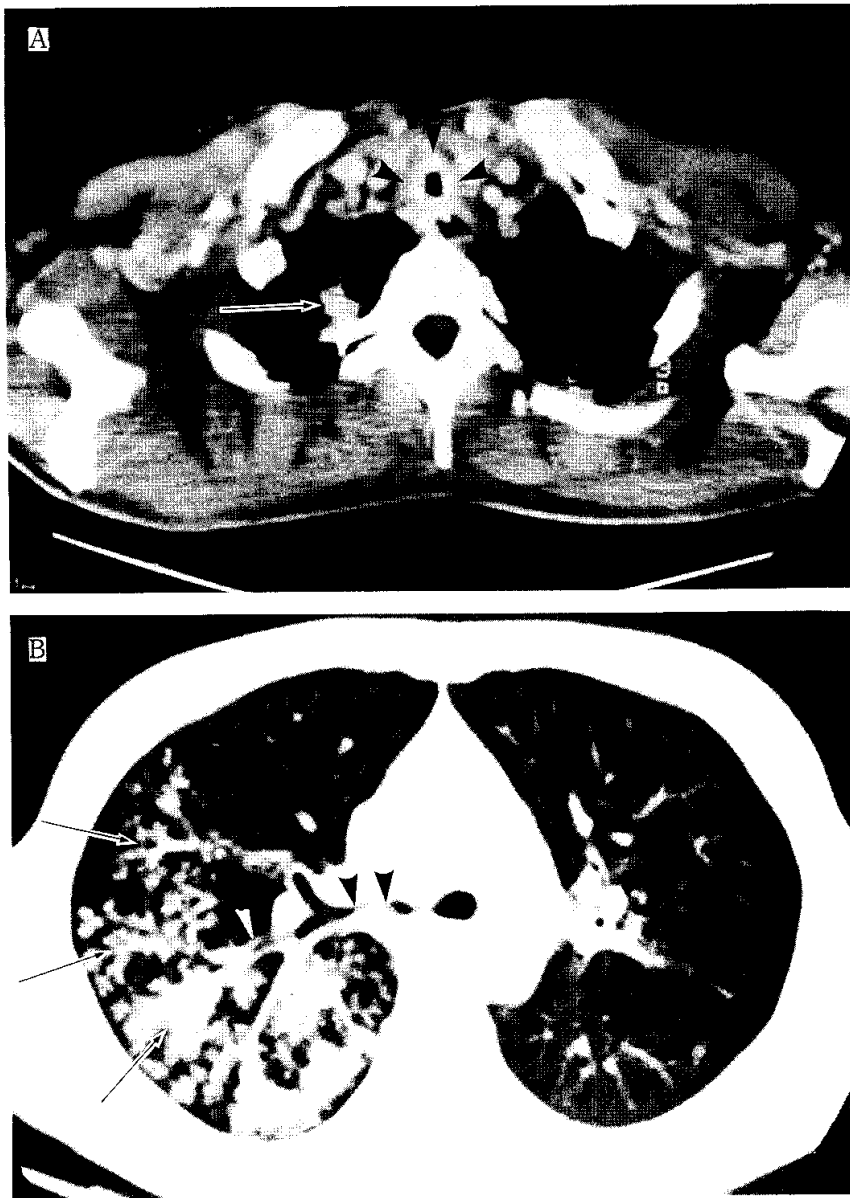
CT scans obtained after injection of intravenous contrast medium in a 35-year-old man with diffuse tracheobronchial tuberculosis. A. Note marked narrowing of the tracheal lumen and enhancing thickened tracheal wall (arrowheads). On bronchoscopy, there were active caseating granulomas on the surface of the trachea and bronchi. Note also nodular pulmonary tuberculous lesion in the right upper lung (arrow). B. Note diffuse narrowing of the right main and upper lobar bronchi with nodular inner surface (black arrowheads). There is thickening of the wall of the posterior segment of the right upper lobe (white arrowhead) and multiple branching linear infiltrations (arrows) distal to the thickened bronchial wall indicating bronchogenic spread.
